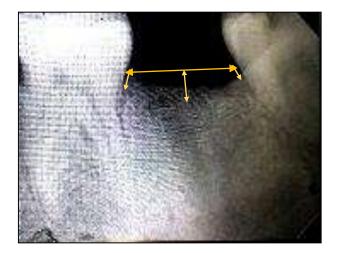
Height of bone- 90th day post operative radiograph with Arrows showing Central, mesial and distal linear measurements
